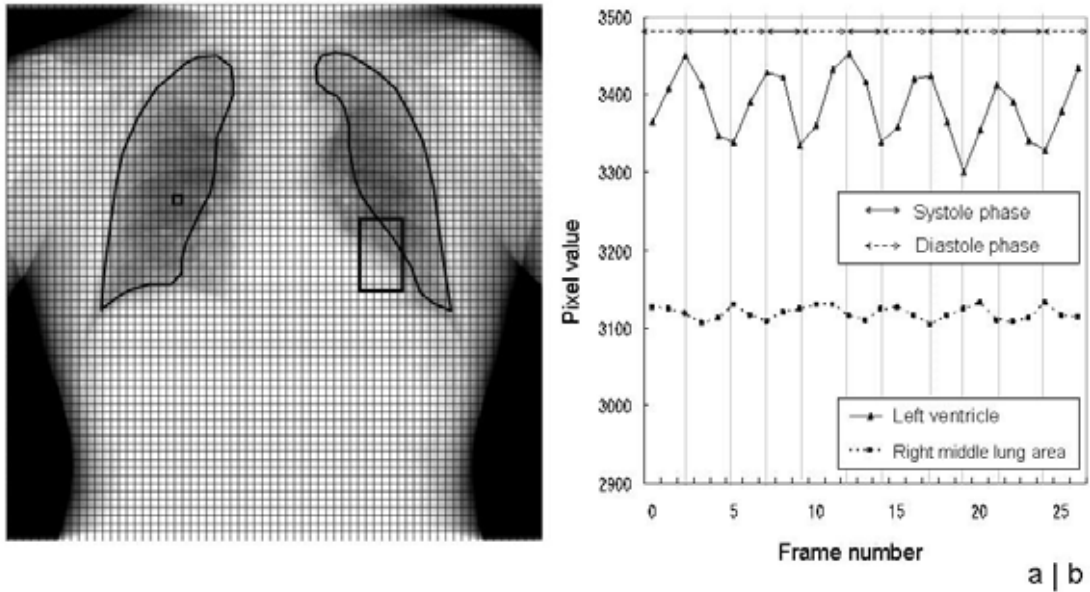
(a) One frame of dynamic chest radiograph (emphysema, 58-year-old man). The black bold lines show the lung area recognized, and the grid lines show the unit of measurement for the local average pixel value. The large square shows the region of interest (ROI) located around the left ventricular wall for determining the cardiac phase. (b) Relationship between average pixel values measured in the ROI located around the left ventricular wall and one block in the right middle lung area.
